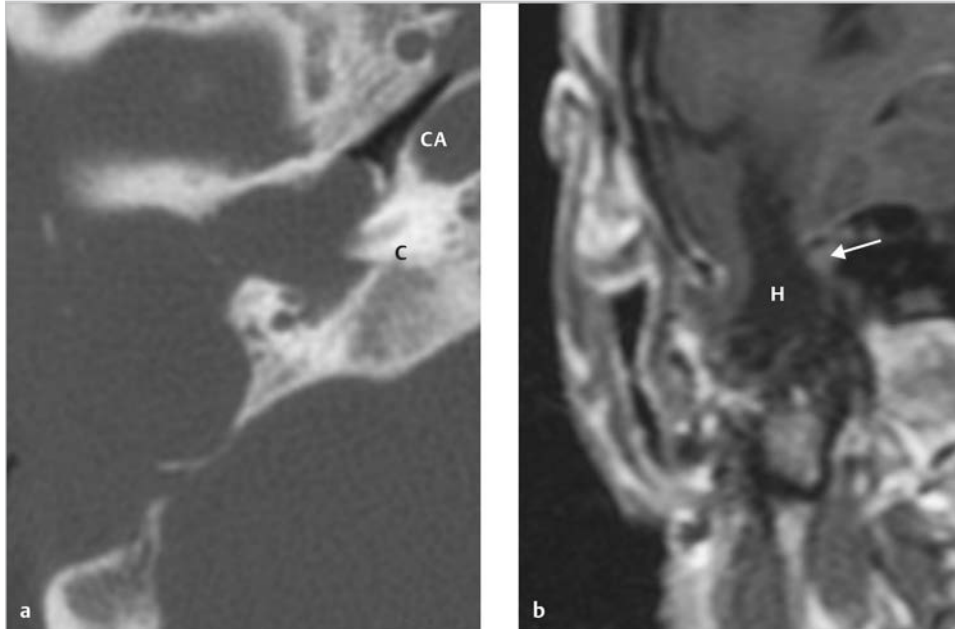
The patient underwent middle ear surgery, which was followed by progressive hearing loss complicated by intractable otorrhea. Otoscopic examination showed a pinkish pulsating mass in the external auditory canal. Radiologic examination revealed meningoencephalic herniation in the middle ear. In the axial CT (a), a large soft tissue with smooth border is seen. The coronal MRI (b) shows herniation of the brain tissue into the middle ear from the defect in the middle fossa plate (arrow). C, cochlea; CA, carotid artery; H, herniated tissue.
